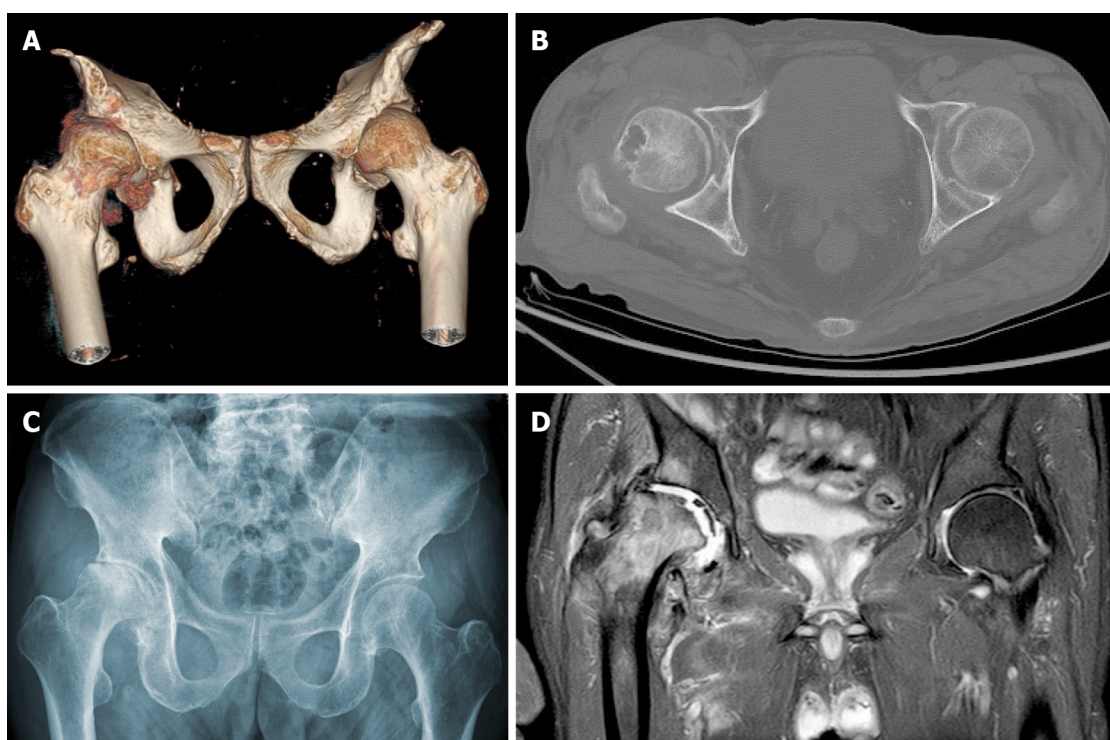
Right hip joint. A: Computed tomography (CT) three-dimensional reconstruction; B: CT; C: X-ray. Joint space loss, articular surface collapse, and destructive acetabulum and femoral head changes; D: Right hip magnetic resonance imaging, T2W1. Articular cartilage loss, joint degeneration, soft tissue disorder, and obvious joint fluid were observed.
